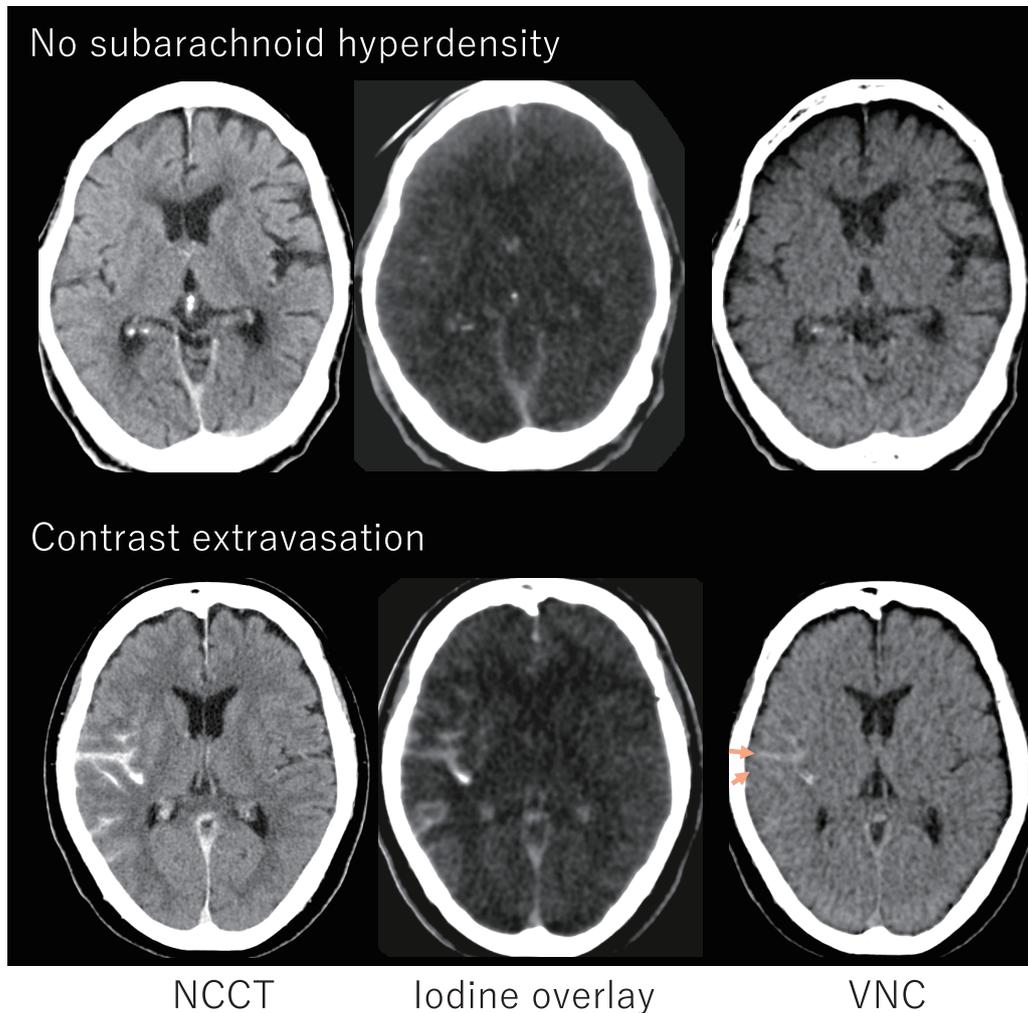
Representative cases of contrast extravasation on dual-energy CT-derived NCCT, iodine overlay, and VNC maps. NCCT: non-contrast CT; VNC: virtual non-contrast
